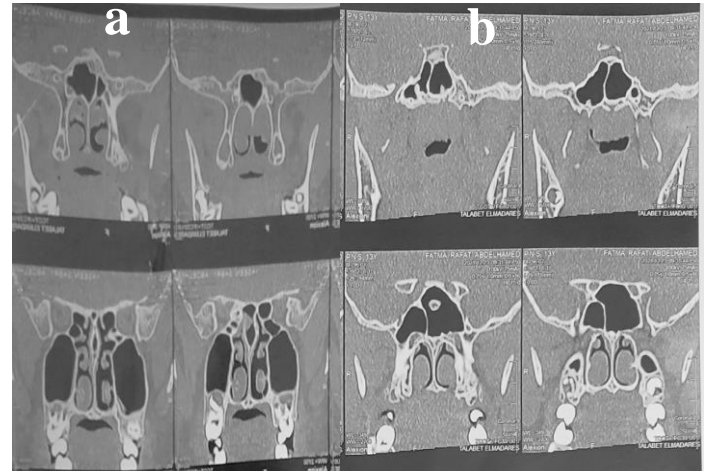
Computed tomography (Coronal section) showing: a) Unilateral HIT & Hypertrophied adenoids, b) Bilateral HIT & Hypertrophied adenoids.
